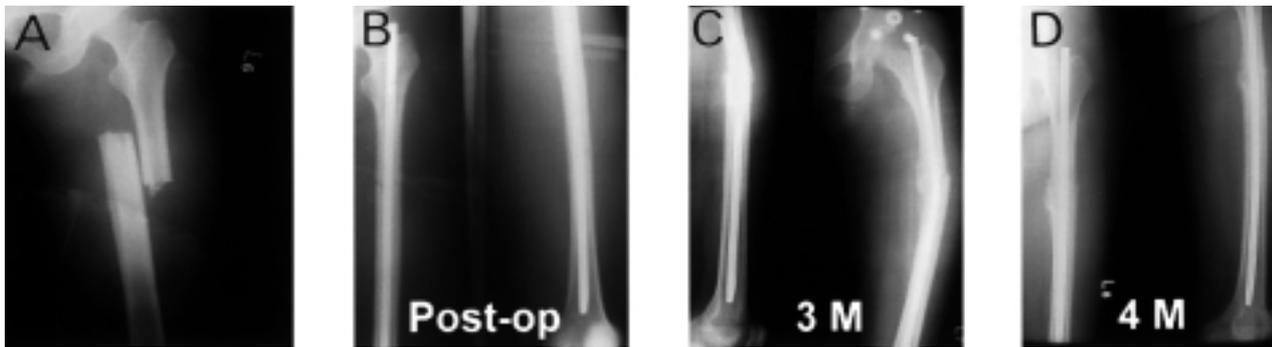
(A) Preoperative radiograph of a Winquist-Hansen type 0 fracture. (B) Postoperative radiograph. (C) The Kuntscher nail is bent 3 months after surgery. We exchanged the nail immediately. (D) Healing callus formation.
